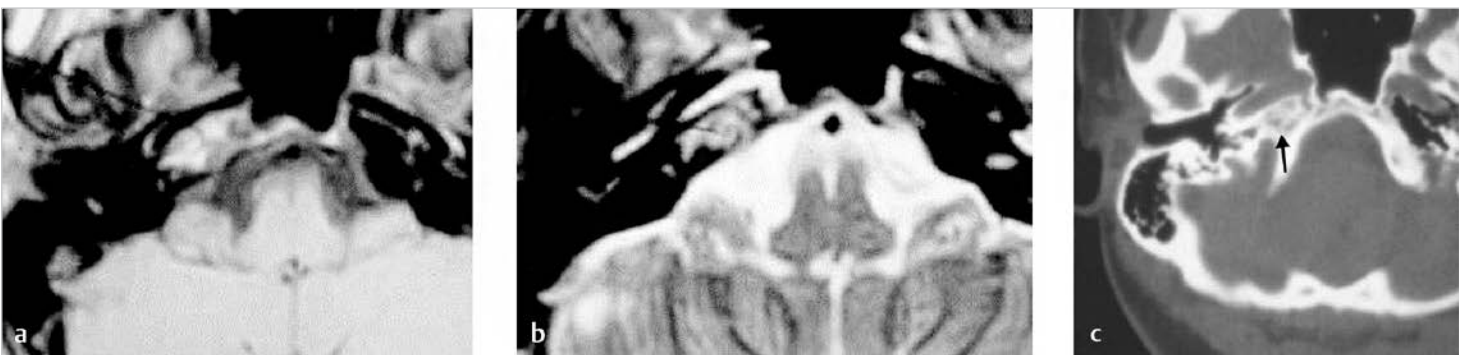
Imaging of a case of right petrous apex effusion. A hyperintense lesion involving the petrous apex is seen on both T1 without (a) gadolinium and (b) T2 image. Note that there is no expansion of the petrous apex. (c) The CT scan shows preserved bony septa between apical air cells.
